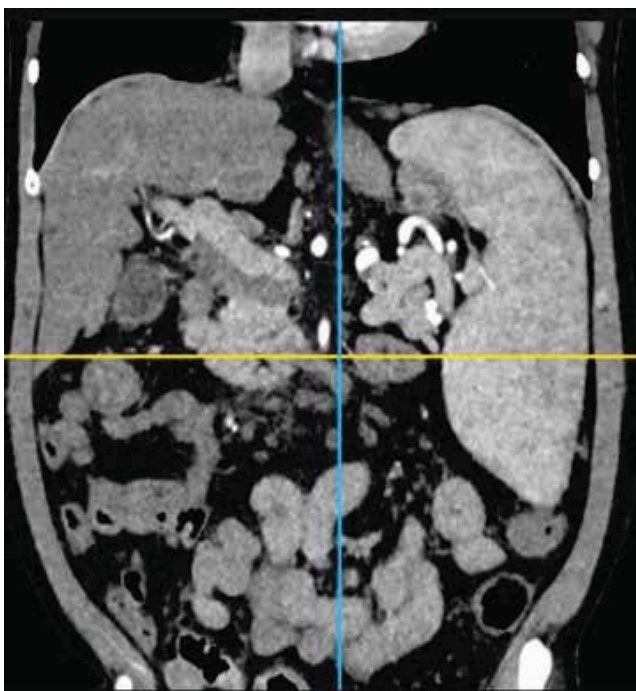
CT: marked splenomegaly, a nodular liver contour, a patent portal vein, and dilated looping splenic artery segments indicating hyperperfusion
